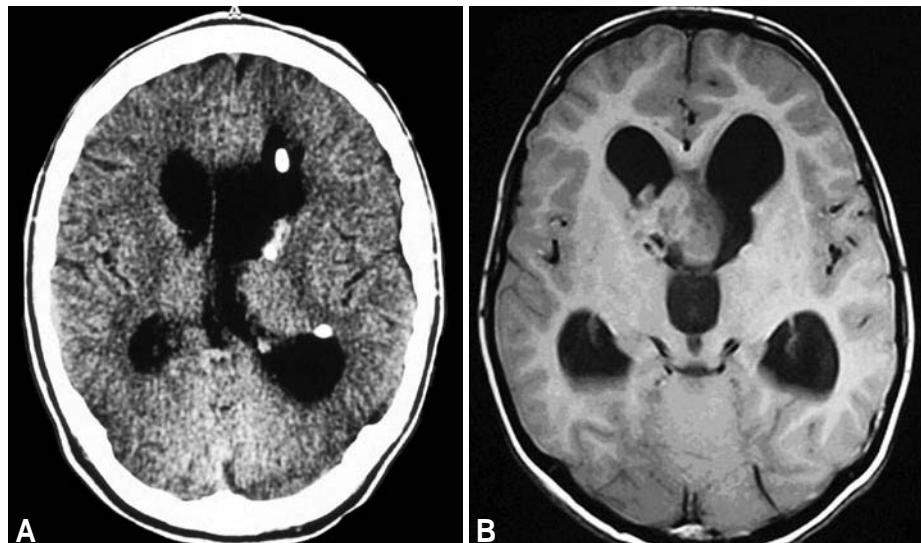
A CT of typical subependymal calcifications in a patient with tuberous sclerosis. B A T1-weighted MRI showing mixed iso- and hypodense mass.
